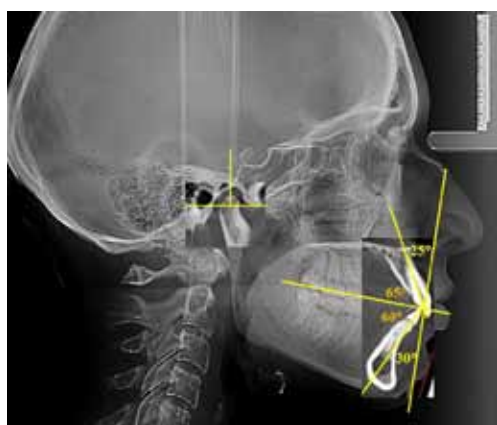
Measurement of the incisors inclination angles and evaluation of the joint position on the combined radiographs
